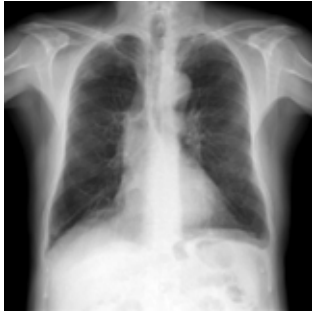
Chest X-ray showing dilated mediastinum.
